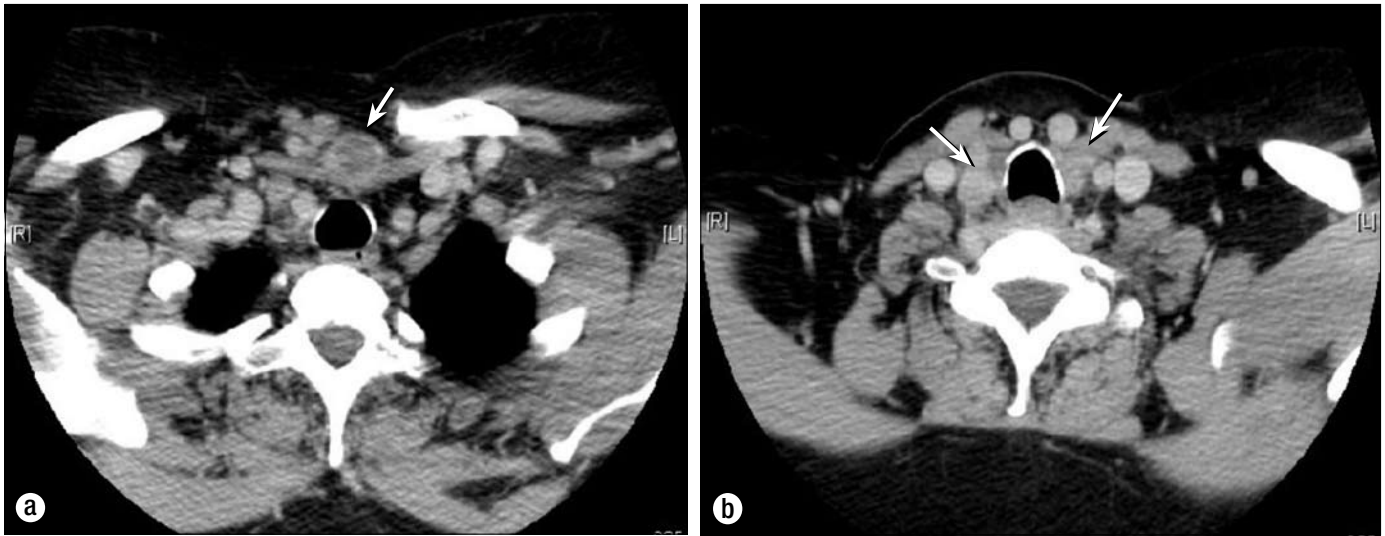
CT scan in September 2009 showing (a) a necrotic suprasternal mass (arrow) penetrating through the sternothyroid/sternohyoid muscles and (b) the extent of bilateral disease in the thyroid bed (arrows).
